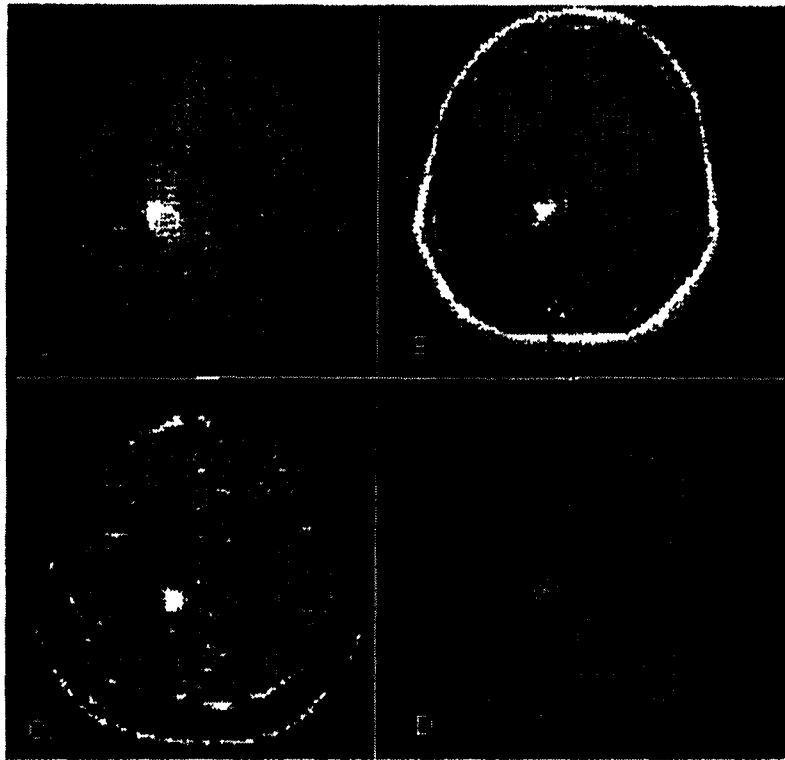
47 y.o. male with known low grade oligodendroglioma status post treatment, now with new enhancement on routine MRI. A. T2-weighted image. B. Post-Gd T1-weighted image. C. rCBV map showing high rCBV focus. D. 18FDG PET showing increased metabolic uptake. Biopsy showed anaplastic astrocytoma.
